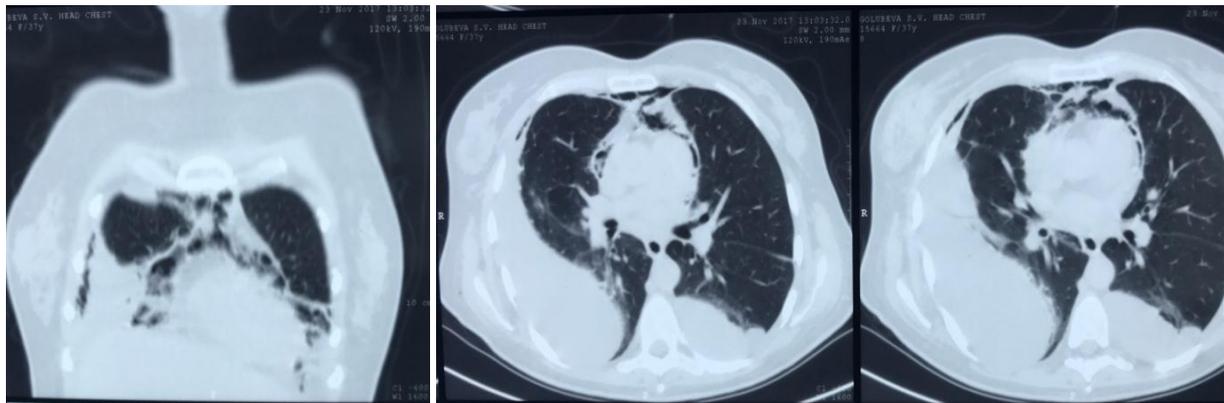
Chest CT of the patient on the third day after hospitalization: signs of air in the mediastinum, pleural and pericardial effusion
